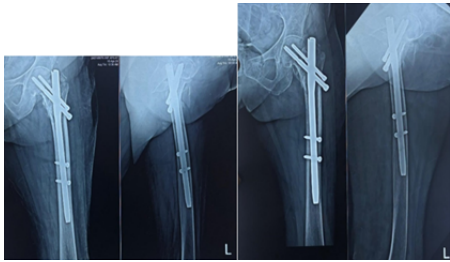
Months And 2 Months Follow Up X-ray
